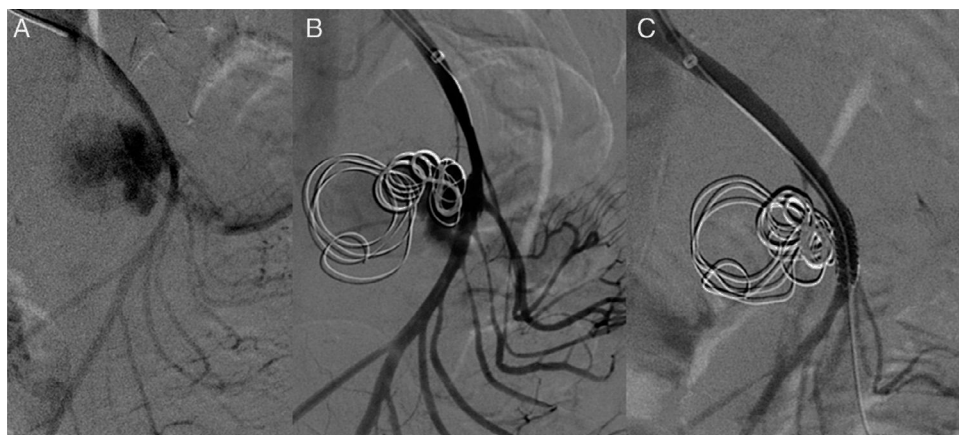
Selective arteriogram: (A) permeability of the PSMA; (B) embolisation of the sac with coils, and (C) placement of the stent.
